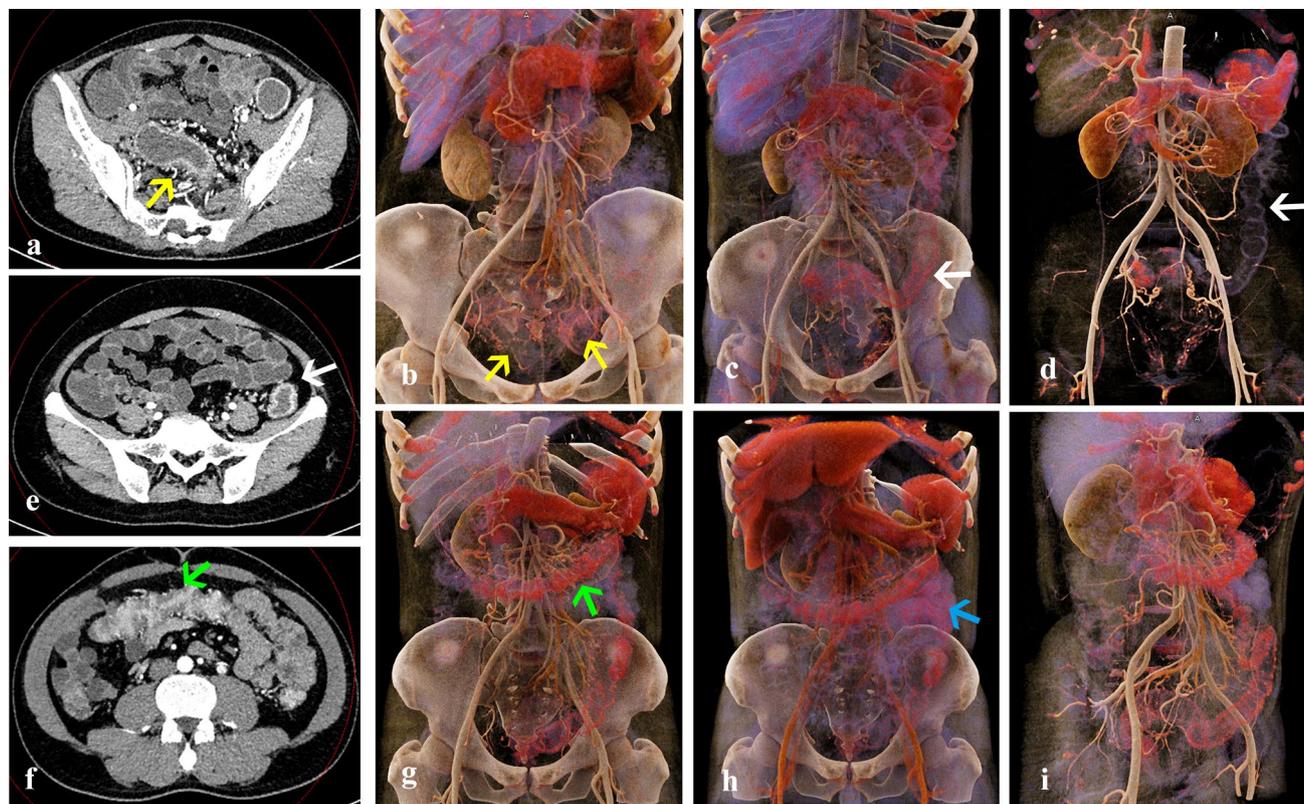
Different extents of UC on CR and axis contrast CT. a, b Mild UC (yellow arrows) in the sigmoid colon; c–e Moderate UC (white arrows) in the colon on the left side; f–i Severe UC (green arrows) in the transverse and descending colon; d, i The bones were removed
